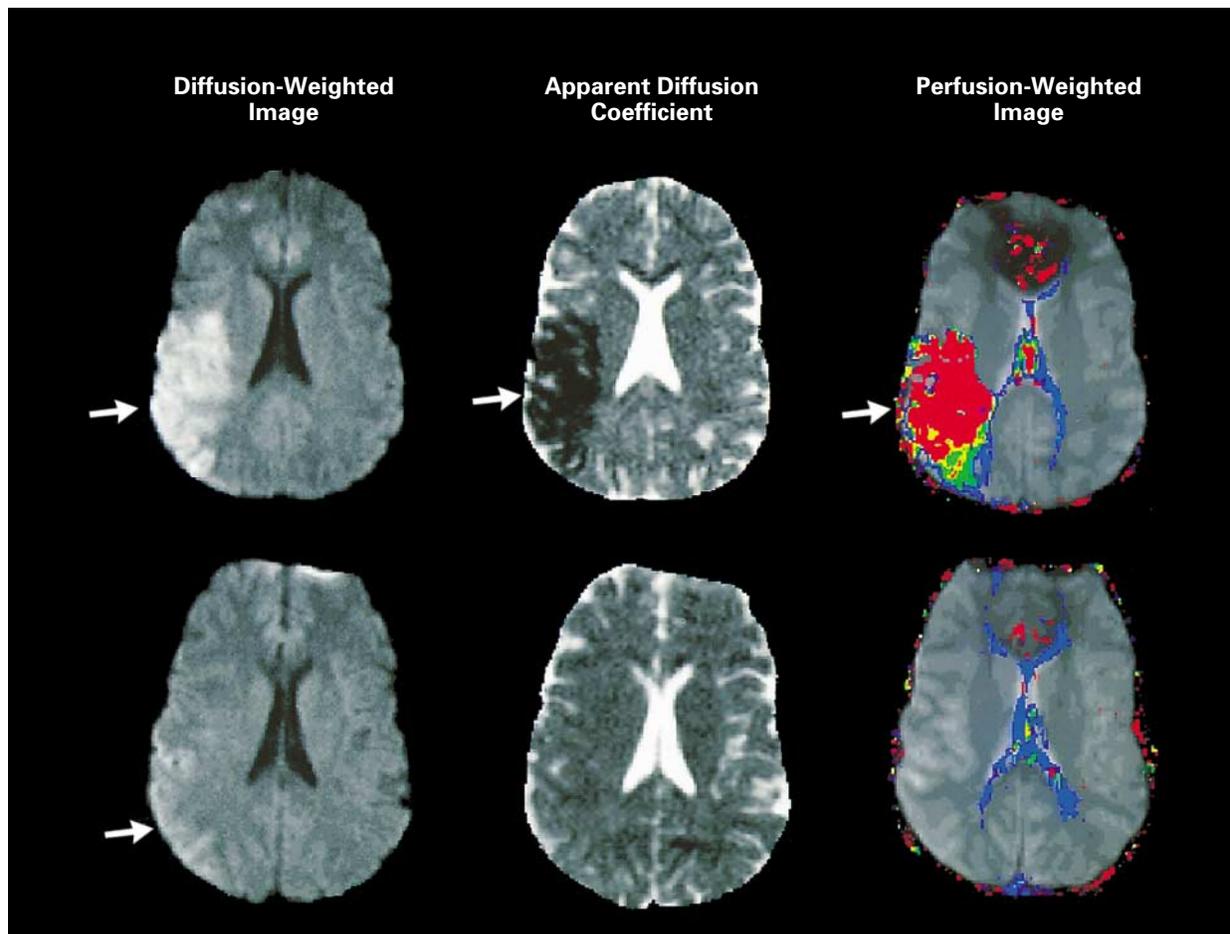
MRI Study Showing Improvements in Diffusion and Perfusion Abnormalities in the Right Cerebral Hemisphere after Intraarterial Administration of Tissue Plasminogen Activator in a 27-Year-Old Woman with Left Hemiparesis.
